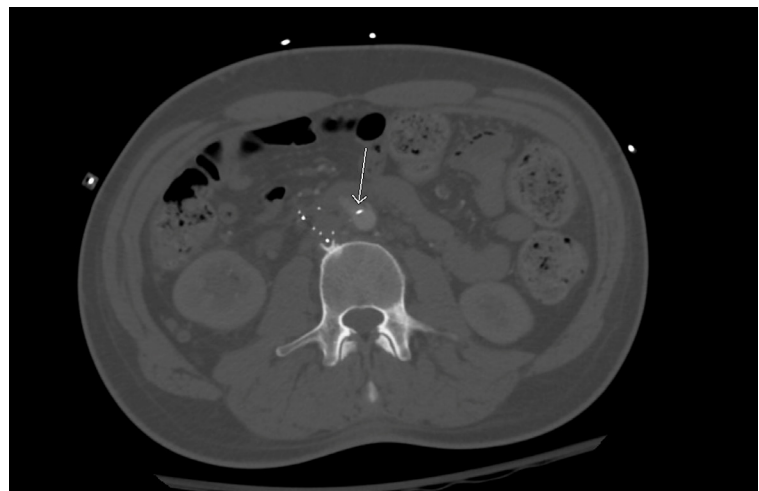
CT angiogram, axial view, showing a strut penetrating the wall of the aorta at the level of the third portion of the duodenum.
